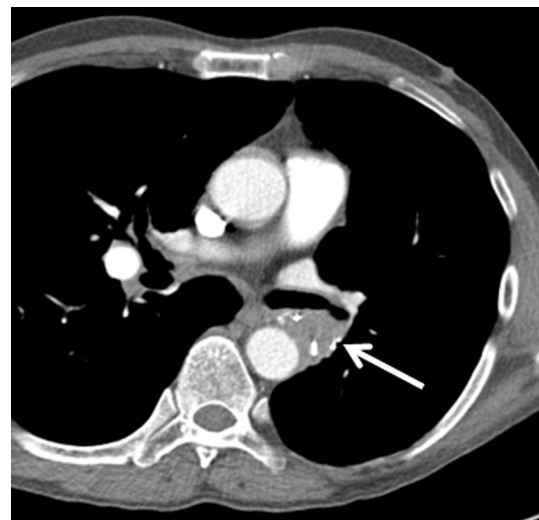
Tumor recurrence in a 61-year-old man who underwent left lower lobectomy for squamous cell carcinoma. Axial chest CT image shows soft-tissue mass (arrow) in the lobectomy stump confirmed by bronchoscopy-guided biopsy
